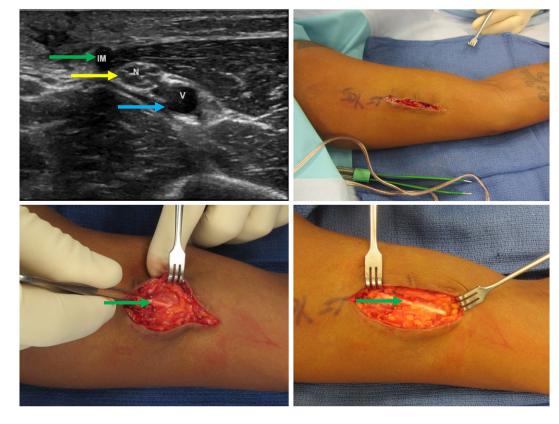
Patient 1: 36 years old (BMI 18.3), multiple extraction attempts and significant pain. Clockwise from top left: (a) Ultrasound image with proximity to neurovascular structures; note nerve fascicles directly abutting the implant in cross section. (b) Initial incision; note transverse scars (black arrows) from prior extraction attempts. (c) Wide exposure of the implant with significant scarring. (d) Removal of the implant. Green arrow marks the implant, yellow marks nerve, and blue marks blood vessel (printed with permission ©2016 nervesurgery.wustl.edu).
